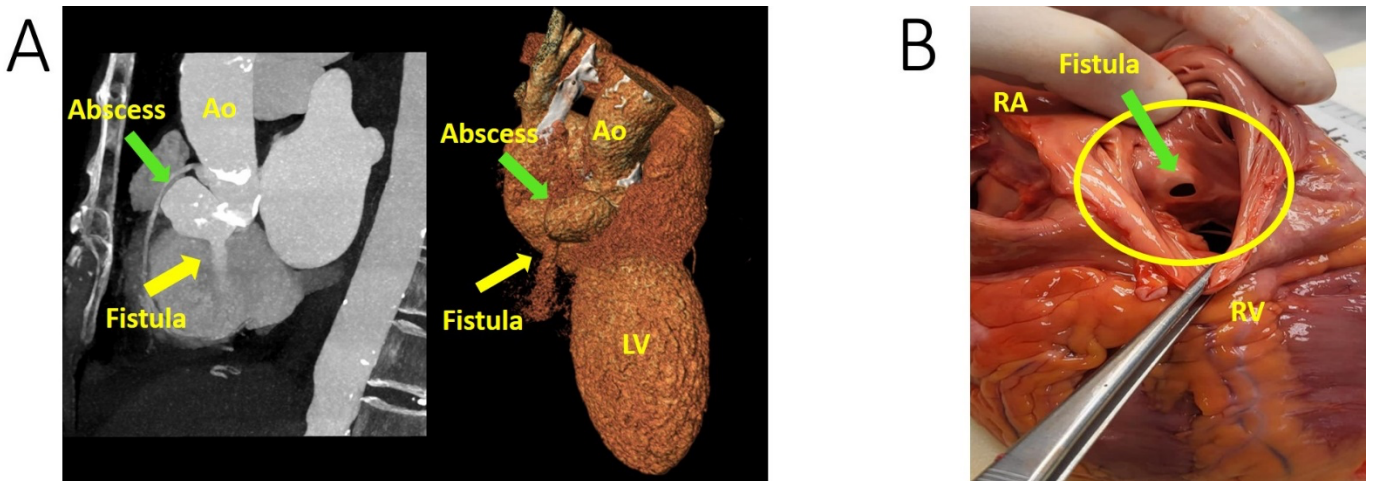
A) Coronary CT: aorto – right atrium fistula. 3D reconstruction of the fistula between the pseudoaneurysm (green arrow) of the aorta and right atrium. The yellow arrow point it out the jet between the abscess and RA. The right chambers were removed from the heart; B) autopsy findings: fistula from the aorta into the right atrium. Ao, aorta; LV, left ventricle, RA, right atrium; RV, right ventricle
